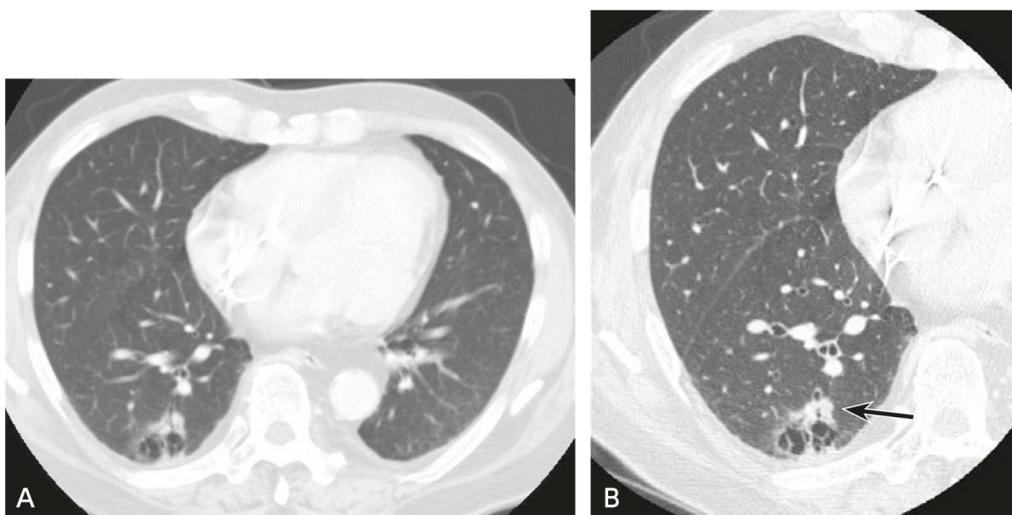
Assessment of lung nodule attributes using HRCT
